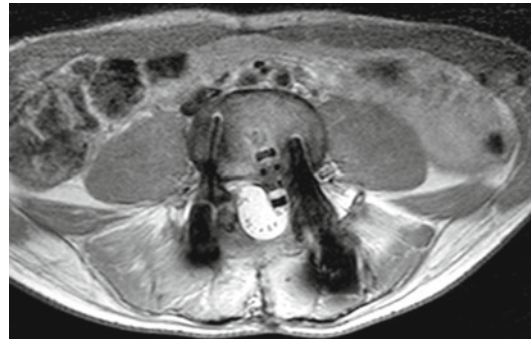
Axial MRI of L-spine showing extruded interbody graft causing canal compromise
